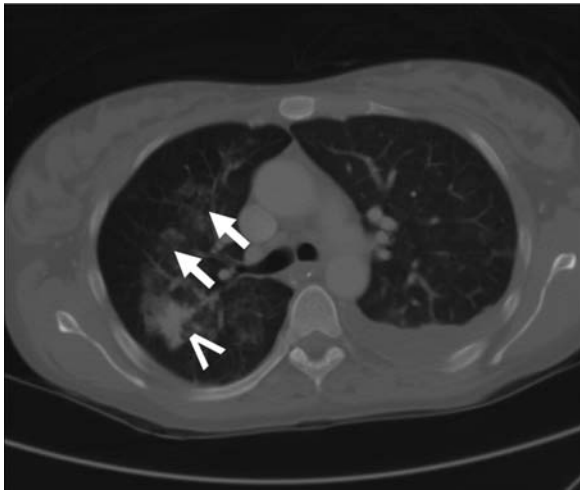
Chest computed tomography shows centrilobular ground-glass nodules (arrows) and consolidations with a heterogeneous aspect (open arrows).
